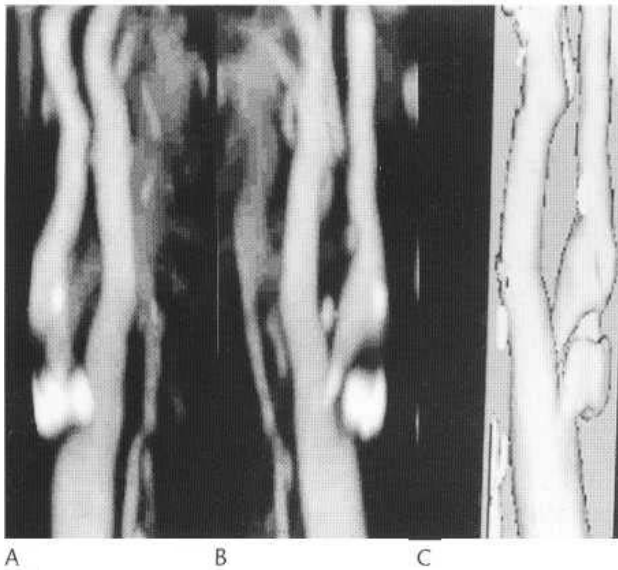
Spiral CT of the neck vessels showing sequestered study of right carotid bifurcation. (A) In the AP view the stenosis is obscured by a calcified plaque. (B) The image is computer rotated through 180° to show the stenosed lumen. (C) 3D CT reconstruction. (Courtesy of Dr A. Al-Kutoubi.)
